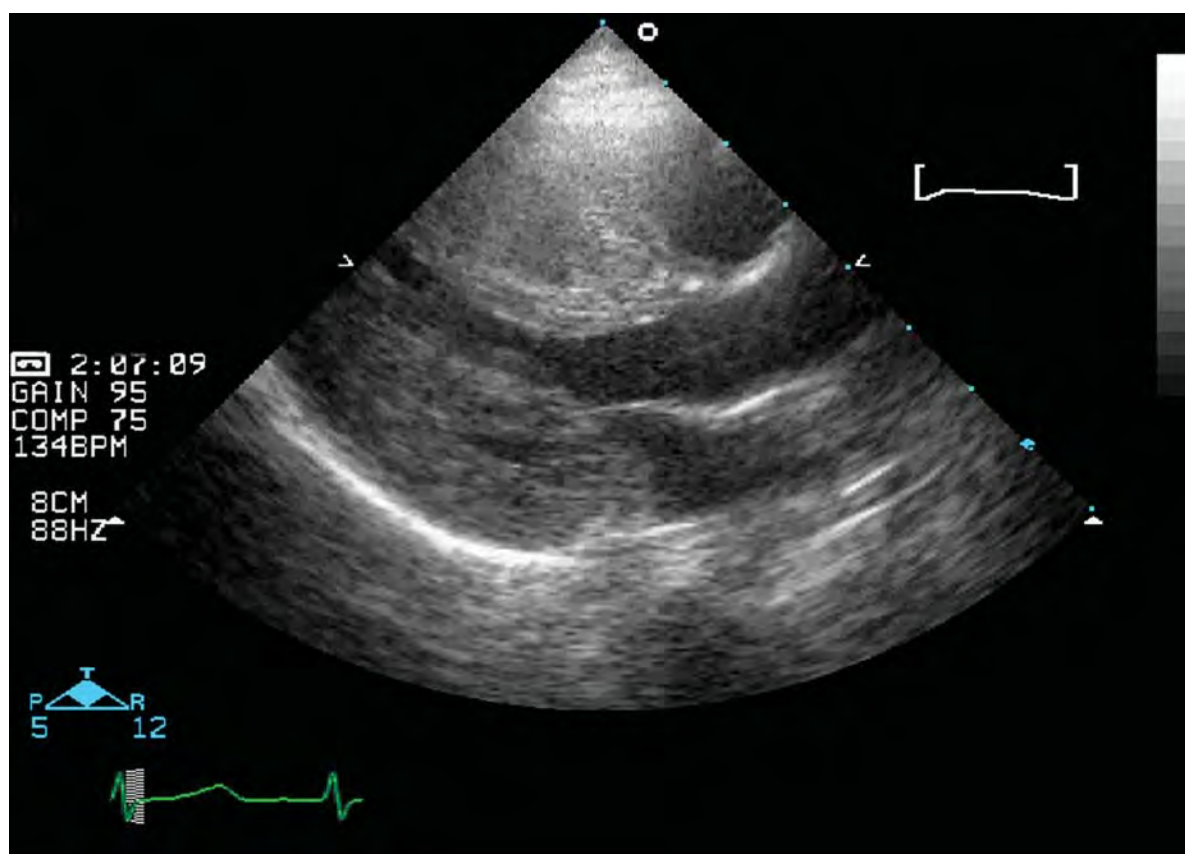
Parasternal long-axis view showing severe septal hypertrophy and mid cavity narrowing.
